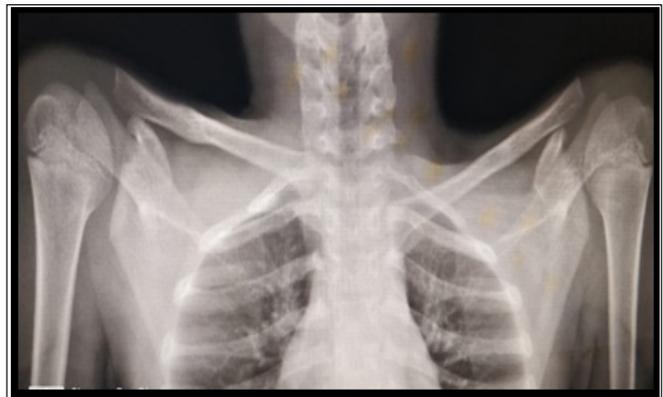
Plain radiography showing dislocation of left sternoclavicular joint
